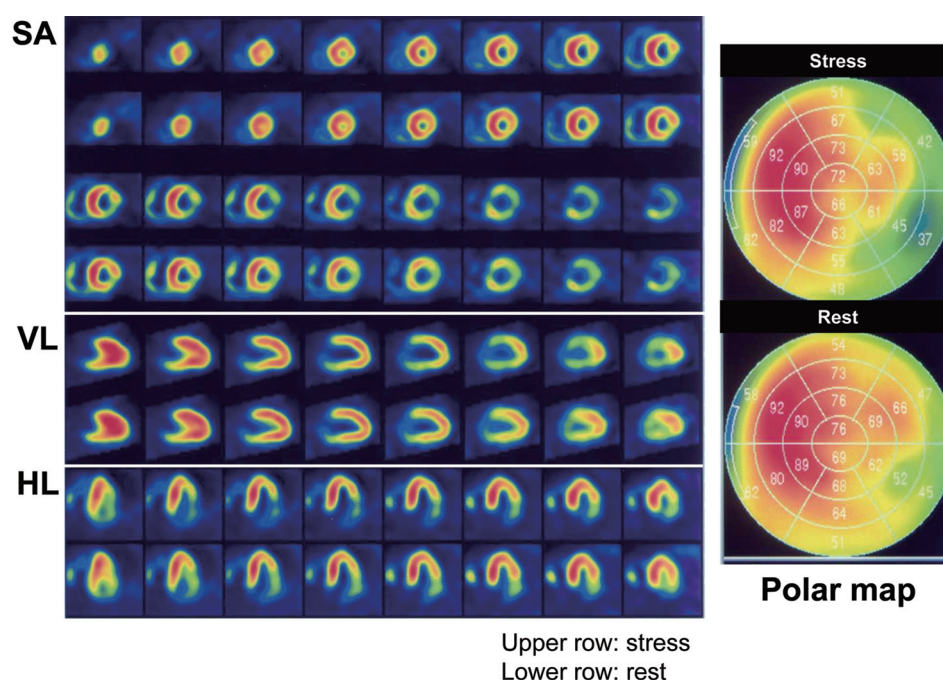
Representative case in which stress myocardial perfusion SPECT (MPS) was useful for the detection of CAV
